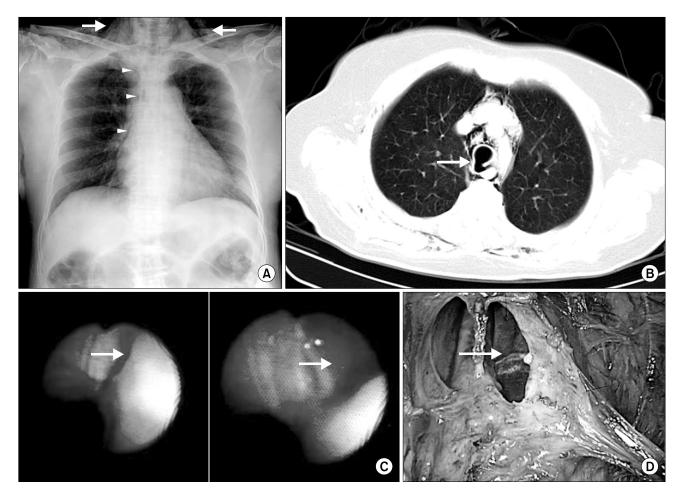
A chest film shows subcutaneous emphysema of the neck and pneumomediastinum (A), and computed tomography scans of the chest show subcutaneous emphysema and disappearance of tracheal posterior membranous wall continuity (B). A fiberoptic bronchoscope reveals a linear tracheal laceration of the posterior membranous wall at the distal part of the trachea (C). Intraoperative photographs show a membranous tracheal linear laceration of about 7 cm arising 3 cm from the carina (D).
